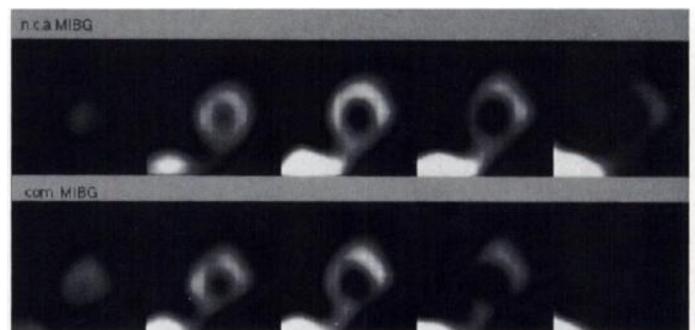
Cardiac SPECT images in a volunteer. Short-axis slices show normal pattern of distribution in all regions of left ventricle from apex to base with n.c.a. and commercial MIBG 4 hr postinjection.
